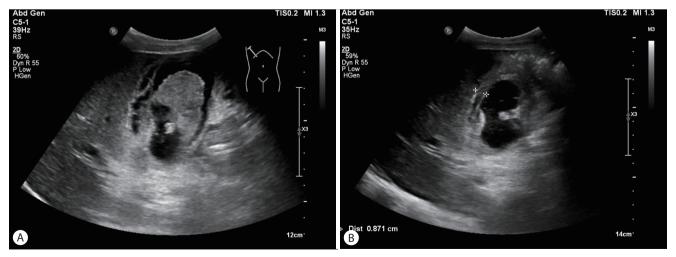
(A) Ultrasound of the gallbladder showed wall irregularity and a mass with nonshadowing nonlayering intraluminal echoes. (B) Gallbladder wall thickening measured 8.7 mm.
